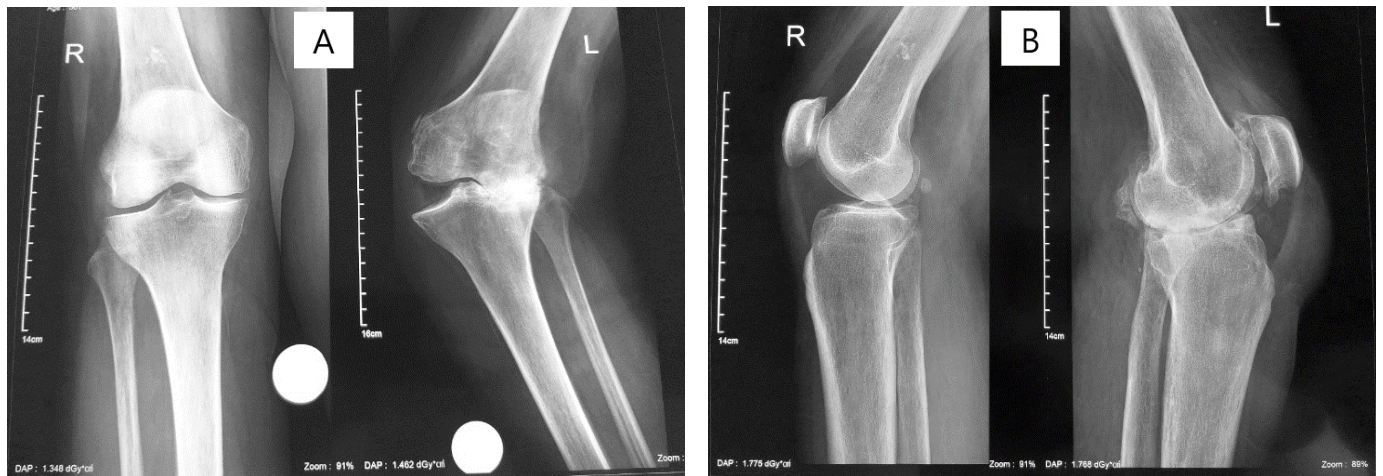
Pre-operative radiographs: A – Anteroposterior (AP) view, B – Lateral view.
